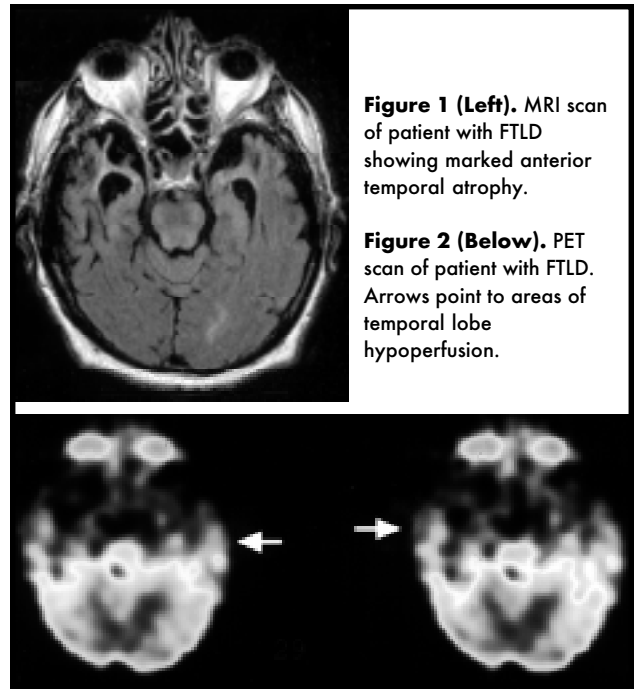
(Left). MRI scan of patient with FTLD showing marked anterior temporal atrophy.
